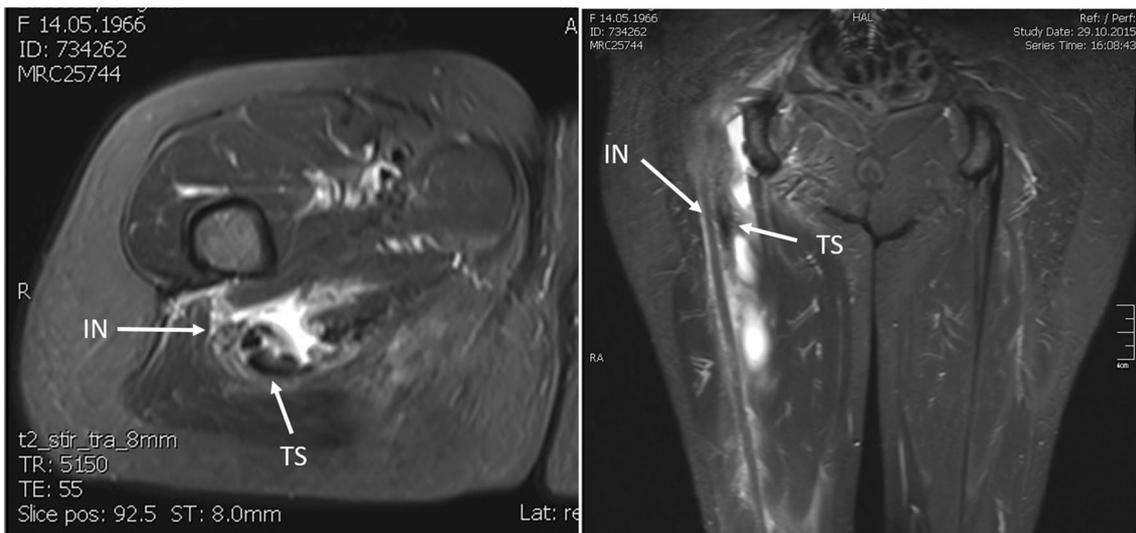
Relevant proximity of the ruptured tendon stump and the sciatic nerve on axial and coronar MRI (T2Stir) in an acute injury of a 49-year-old female patient (IN ischial nerve, TS tendon stump)
